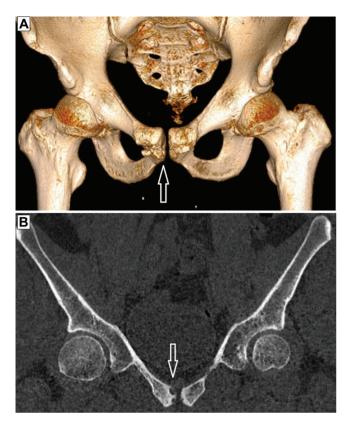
Preoperative (A) 3-dimensional and (B) coronal computed tomography images of a 30-year-old male patient with osteitis publes. Arrows indicate significant degeneration of the public symphysis, subchondral cyst formation, and subchondral sclerosis.
